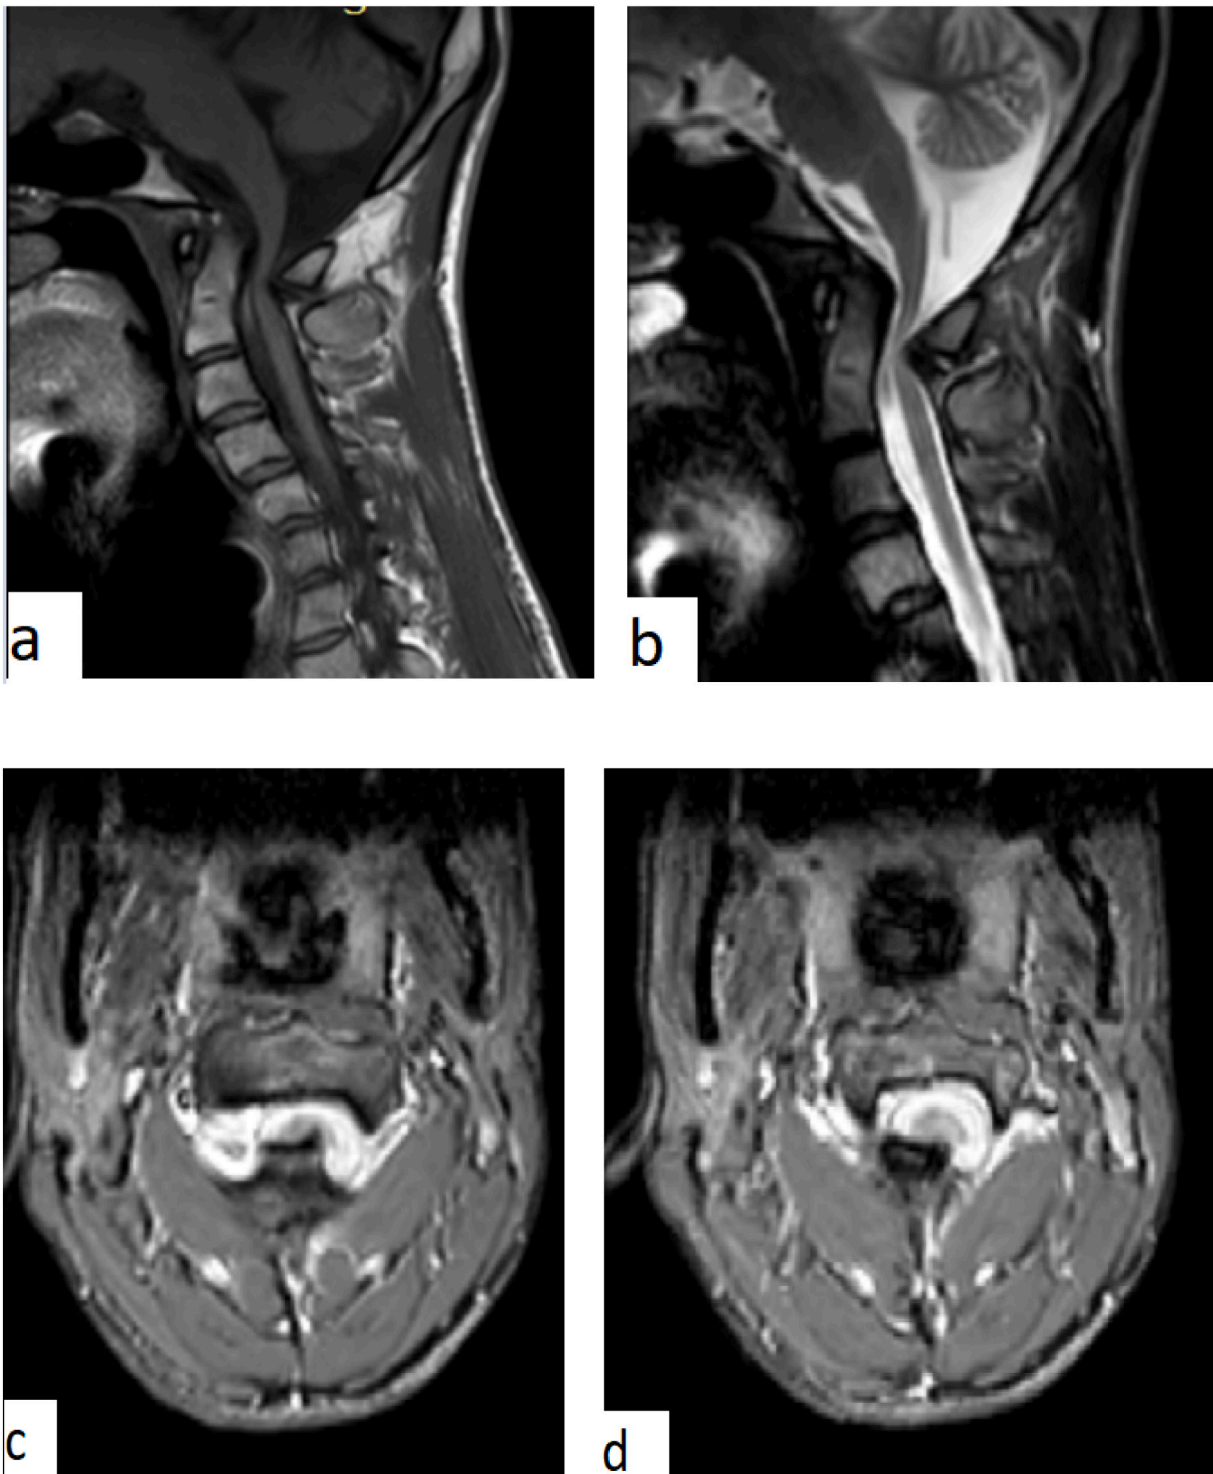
Sagittal T1 (a) and T2 (b) weighted MR images of the cervical spine demonstrate the marked narrowing of the spinal canal at the C2 level. At the compressed level, the axial T2 (c, d) weighted images demonstrating a C2 posterior mass severely compressing the cord.
